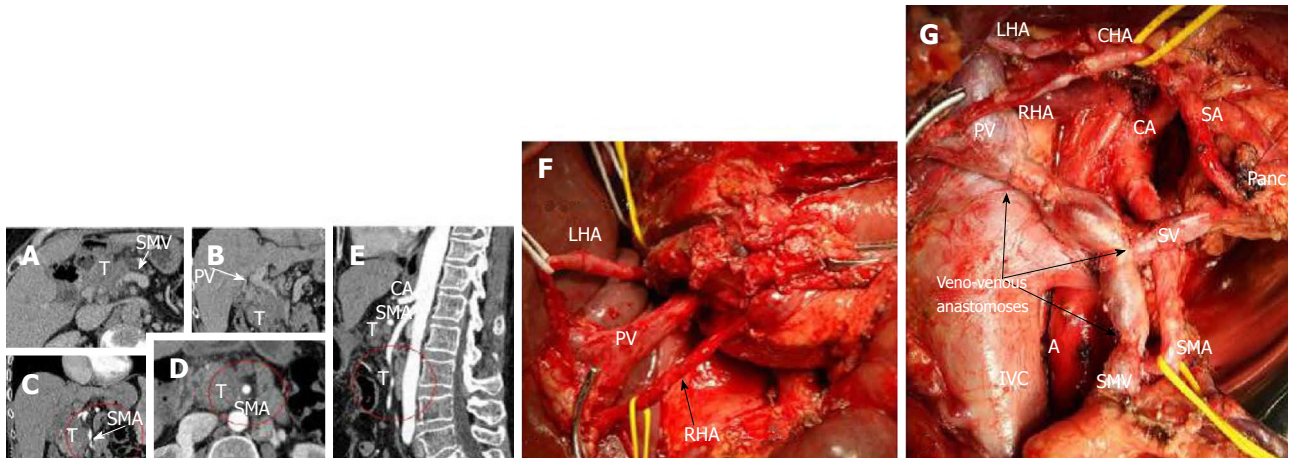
In this 61-year-old woman (case 6), 260° and 360° pancreatic ductal adenocarcinoma encasement of SMA segments was diagnosed on computed tomography (A-E), while endoUS data described only tumor abutment with the superior mesenteric artery. A, B: Venous phase. Sagittal view. Computed tomography provided evidence of circumferential involvement of the SMV and PV; C, E: Arterial phase. Sagittal view. The distal SMA segment (6-7 cm from the origin) presented circumferential adjacency to pancreatic head ductal adenocarcinoma. The celiac artery (CA) was unaffected; D: Arterial phase. Axial image. At least 260° of the proximal SMA segment (2.5-3 cm from the origin) was circumscribed by tumor. An extended Whipple procedure with pancreatic body, portal, splenic and superior mesenteric vein resection was performed with the use of a superficial femoral vein autograft (F, G). Notwithstanding "organoleptic" signs of unresectability (both hepatic arteries were embedded in the tumor) (F), there were no signs of superior mesenteric artery (SMA) or hepatic artery involvement during surgery (G). The level of resection was R1 because of the contact of the SMA with the tumor. A: Aorta; CHA: Common hepatic artery; RHA: Right hepatic artery; LHA: Left hepatic artery; SA: Splenic artery; SMV: Superior mesenteric; PV: Portal vein; LRV: Left renal veins; T: Tumor; Pancr: Pancreatic tail stump.
